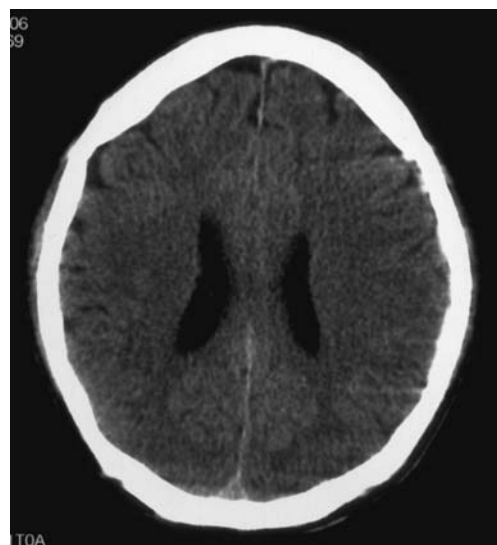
CT scan performed 12 h after admission disclosed the disappearance of hematoma
